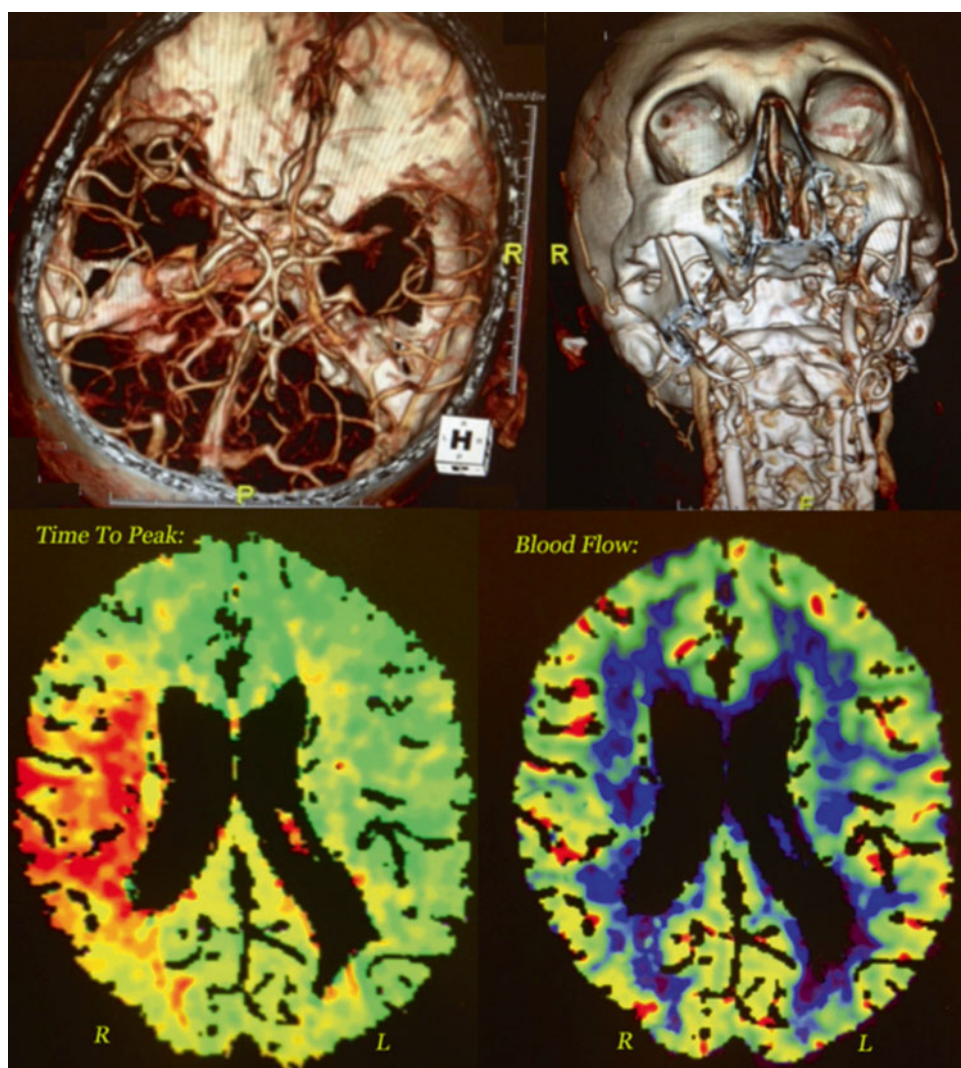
Right MCA ischemia due to occlusion of right ICA complicated by right MCA stenosis as revealed by CT angiography (*upper panels*) with CT perfusion shown in *lower panels*
